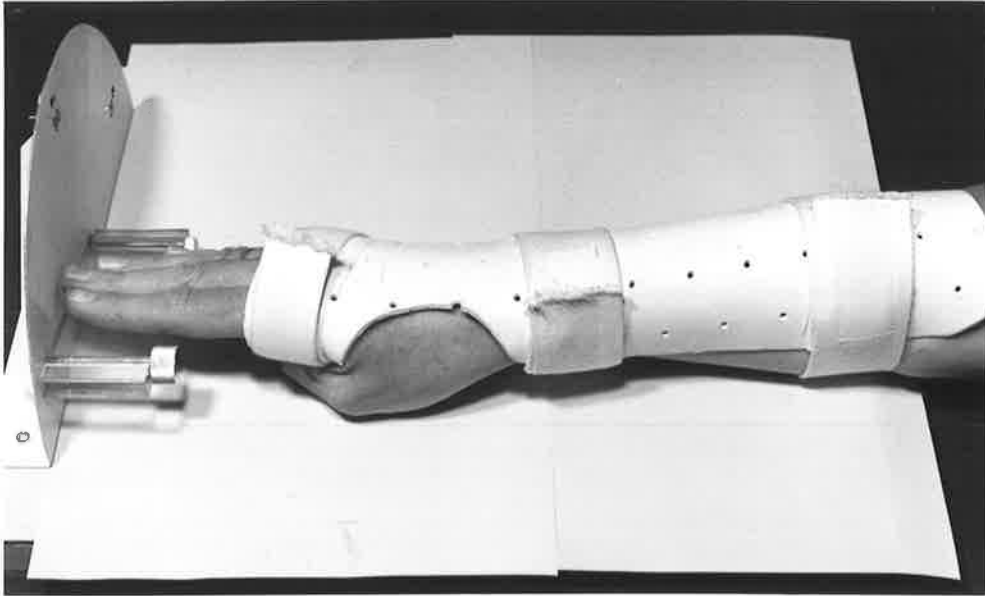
Position of right hand for radiographic measurement of opposition.
